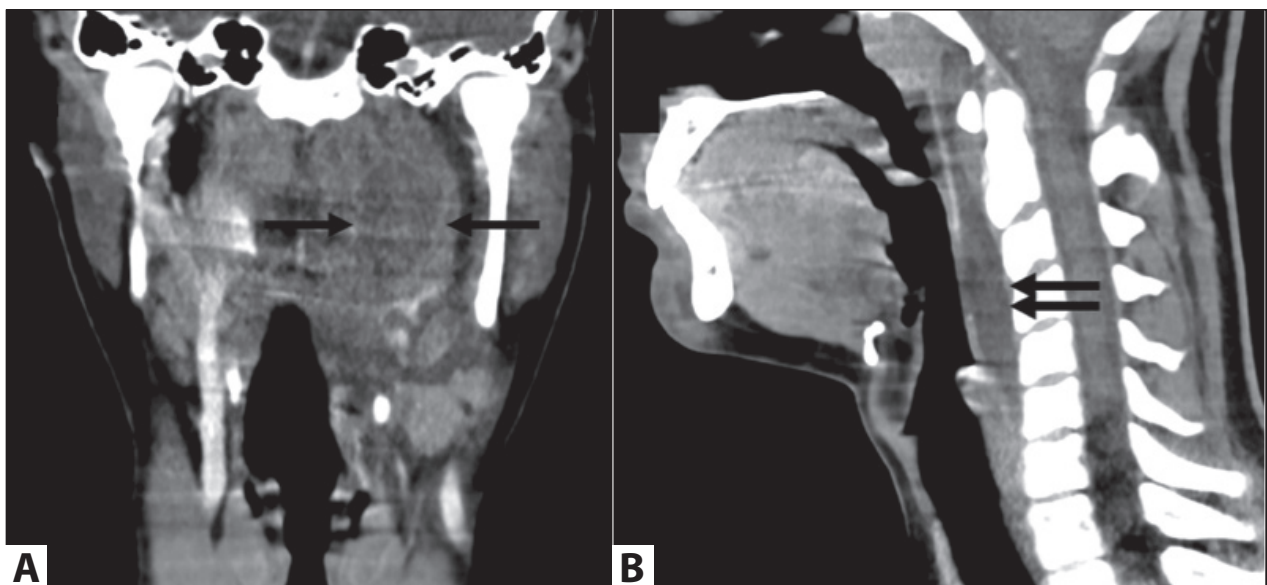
Coronal A. and sagittal B. reformat images of contrast neck CT slices.
